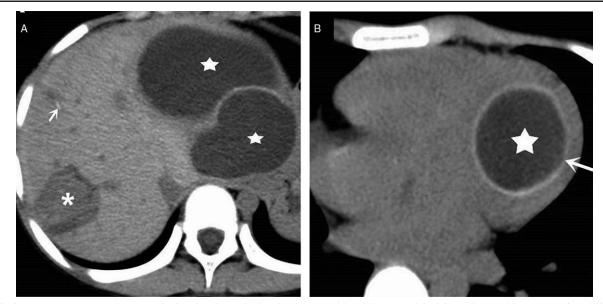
A noncontrast computed tomography imaging shows the imaging features of the abdomen and the left ventricular echinococcosis (asterisk). (A) Two cystic lesions (asterisk) with thin walls, and two slightly lower density lesions, one of which contained heterogenous solid (light asterisk) and another had minimal calcification (arrow). (B) Scanned range shows a cystic lesion in left ventricle, which contained an attenuation density with slightly high-density ring (arrow) due to calcium deposition.
